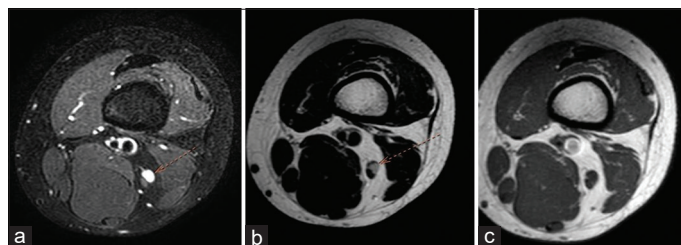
Magnetic resonance imaging scans taken 9 cm above the knee joint showing a lesion of size 5 by 6 by 7 mm within the proximal peroneal division of the left tibioperoneal trunk with nerve fascicular compression. The lesion is hyperintense on fat-suppressed images (a) and T2 sequences (b) and isointense on T1 sequences (c)
